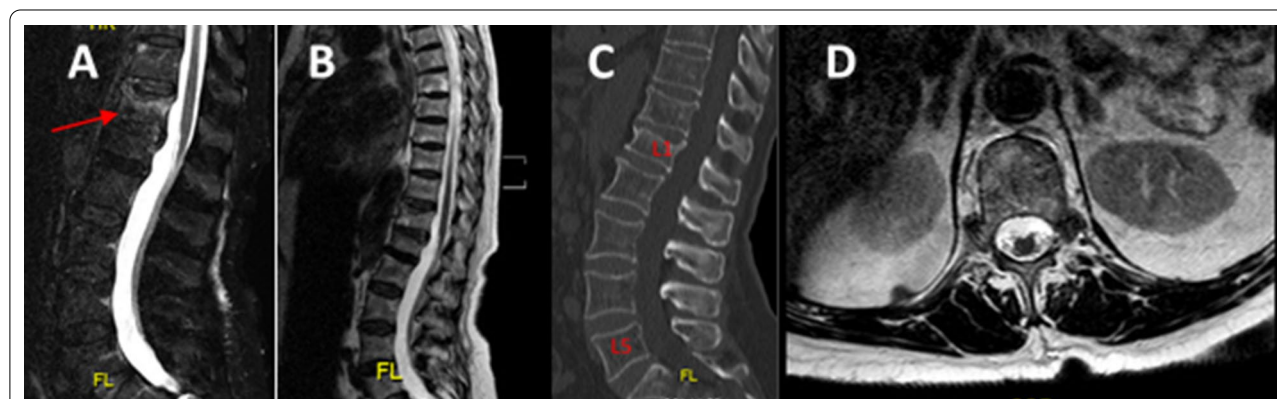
Indication for surgery. 79 y/o female with osteoporotic L1 vertebral fracture. A MRI STIR sagittal sequence, B T2-sagittal sequence, C CT scan, and D axial sequence of L1 without spinal stenosis
